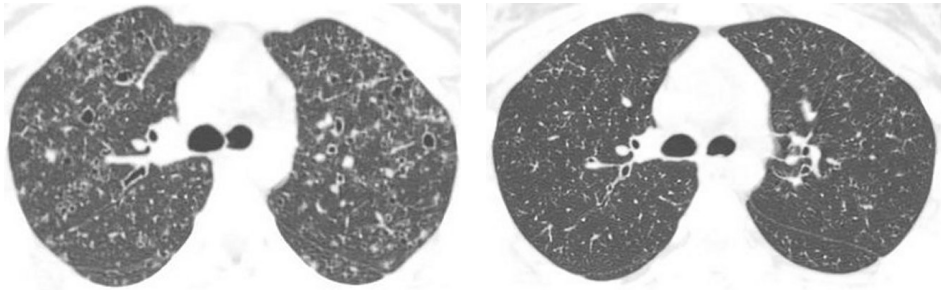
HRCT scan of the thorax of a patient (case #1) with Langerhans cell histiocytosis at presentation showing cyst and micro noduli (left panel) and normalized scan 4 months after stopping with smoking (right panel)
